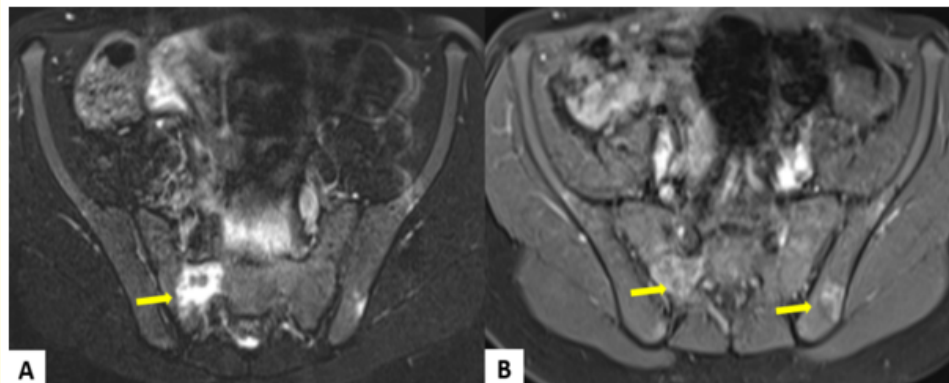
Axial fluid-sensitive (A) and contrast-enhanced fat-suppressed T1-weighted (B) MR images demonstrate focal medullary abnormalities adjacent to the sacroiliac joints, with high signal intensity on the fluid-sensitive sequence and enhancement after gadolinium administration (Yellow arrows). The abnormalities are predominantly intraosseous, without definite MRI features of sacroiliitis or associated soft-tissue collection.
